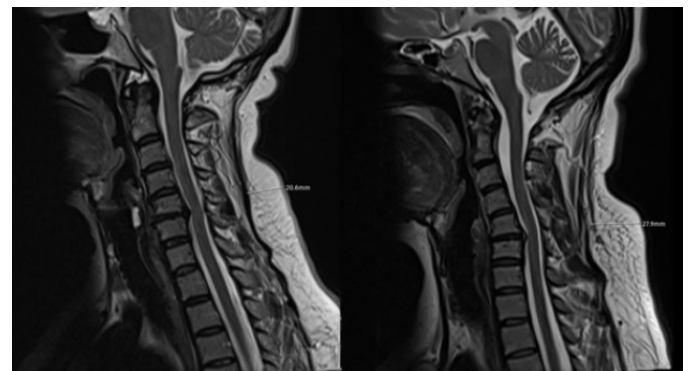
Cervical disc herniation at C5-C6 distance on T2 sagittal section on cervical MRI and demonstration of subcutaneous fat tissue measurement.
